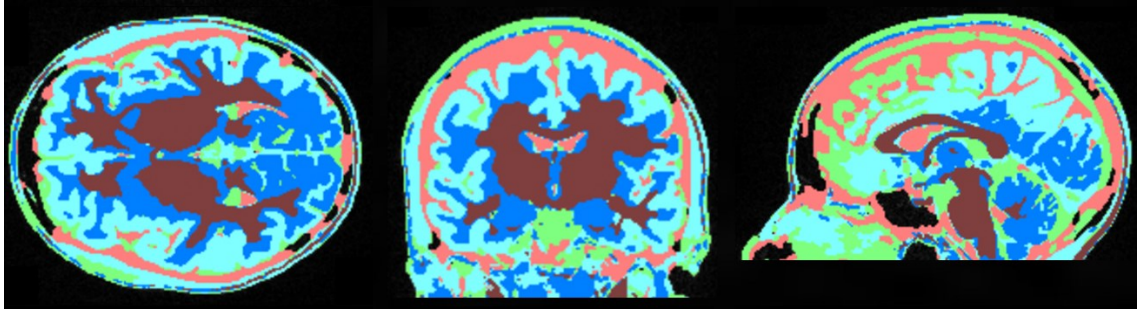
K-means-based segmentation of MRI images in Figure 4.1 without post-segmentation correction ( $k=6$ ).
